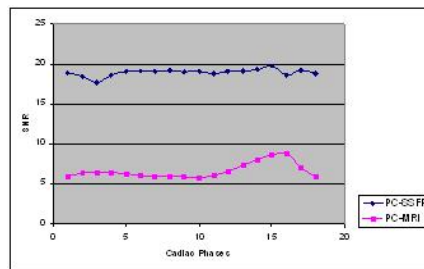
SNR gain as a function of cardiac phase. PC-SSFP yields 3 times higher SNR with less relative signal variation than PC-MRI.
